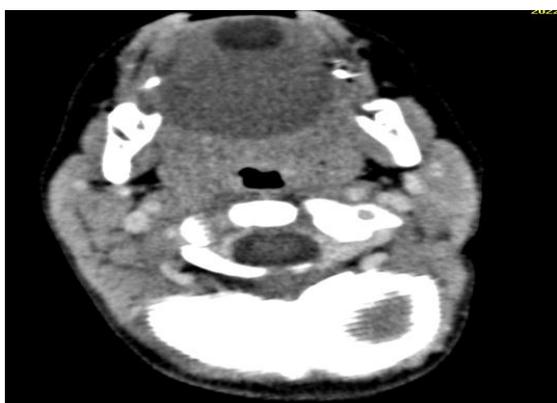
Facial CT scan c+ in axial section: oval formation of fluid and fat density on the dorsal surface of the tongue annularly enhanced after injection of contrast medium, site of a rounded formation of thin-walled fluid density annularly enhanced after injection of PDC
